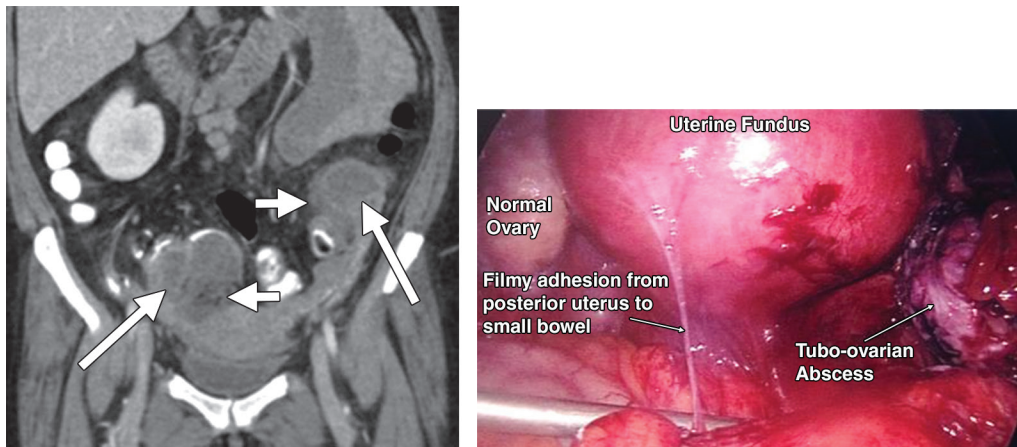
Late PID: tubo-ovarian abscess in two different patients. (a) Coronal contrast-enhanced CT image of a 35-year-old woman presenting with pelvic pain and fever shows bilateral adnexal multilocular septate cystic masses (long arrows) with thick enhancing septa, loss of the normal ovarian parenchyma, and surrounding fat stranding (short arrows). (b) Intraoperative photograph of the posterior pelvis of a different woman shows a right complex hemorrhagic mass compatible with a tubo-ovarian abscess, with a prominent adhesion extending from the uterus to the small bowel. Note the normal-appearing left ovary.
